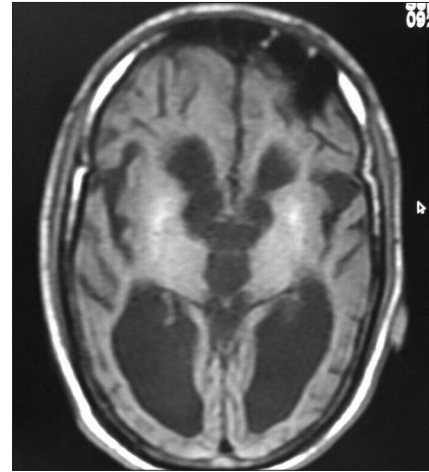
MRI T1W axial image showing diffuse cerebral atrophy, dilated ventricles, decreased volume of gray and white matter, and bilateral symmetrical hyperintense changes in basal ganglia due to soft calcification
